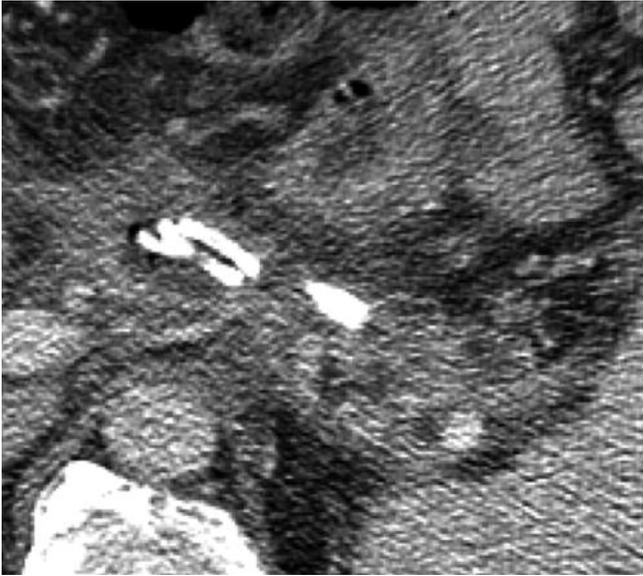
Low-dose CT control, a fortnight later: the collection still recedes.
